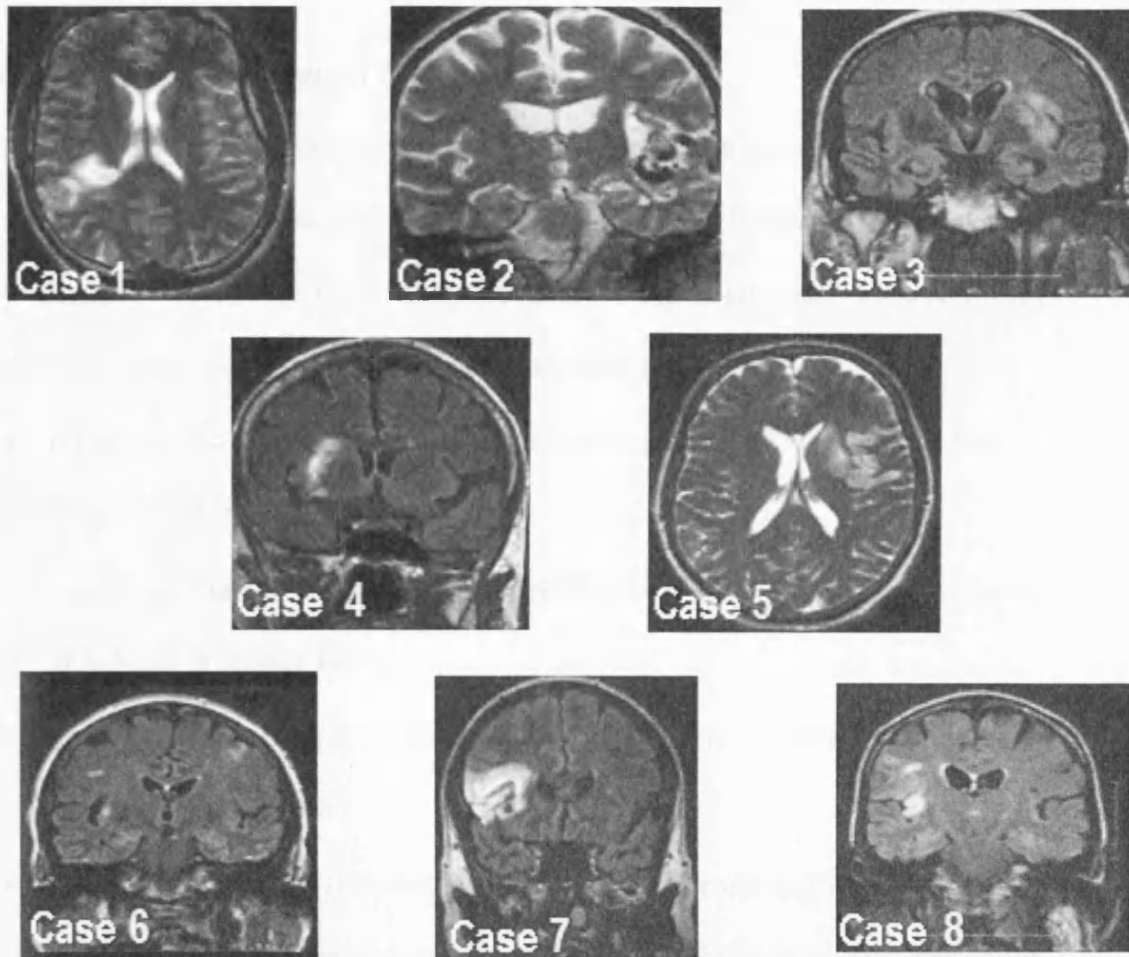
Fast spin echo (T2W) TR 6000 ms TE/EF 106, axial (case 1, case 5) and coronal acquisition (case 2) images. Fluid attenuated inversion recovery (FLAIR), TR 10,000 ms, TI 2500, coronal acquisition images (cases 3, 4, 6, 7, 8).
